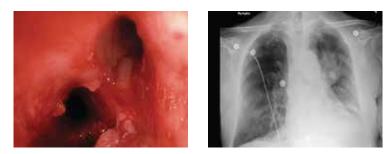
Bronchoscopy and radiography post-PHOTOFRIN® (porfimer sodium) for Injection treatment.
